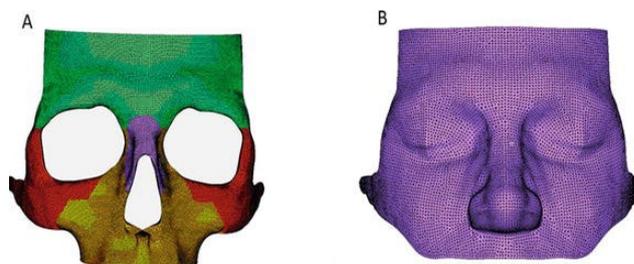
A CT image of the bone(A) and soft tissue(B) of the face [16].
